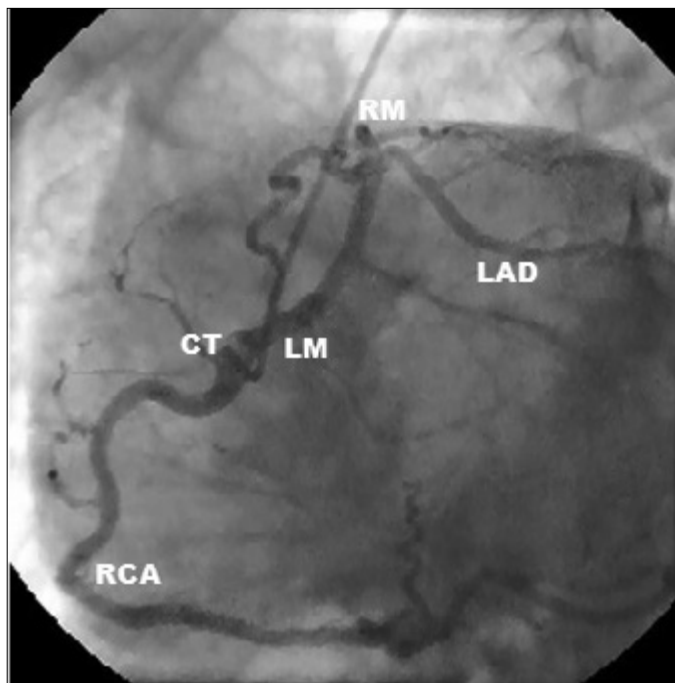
Angiogram obtained from a 52-year-old woman in the left anterior oblique cranial projection. In this view, the entire coronary system is visualized from a single ostium that is located at the right sinus. Common trunk (CT), left main trunk (LM), septal branch (SB), left anterior descending (LAD), and ramus (RM) branches
